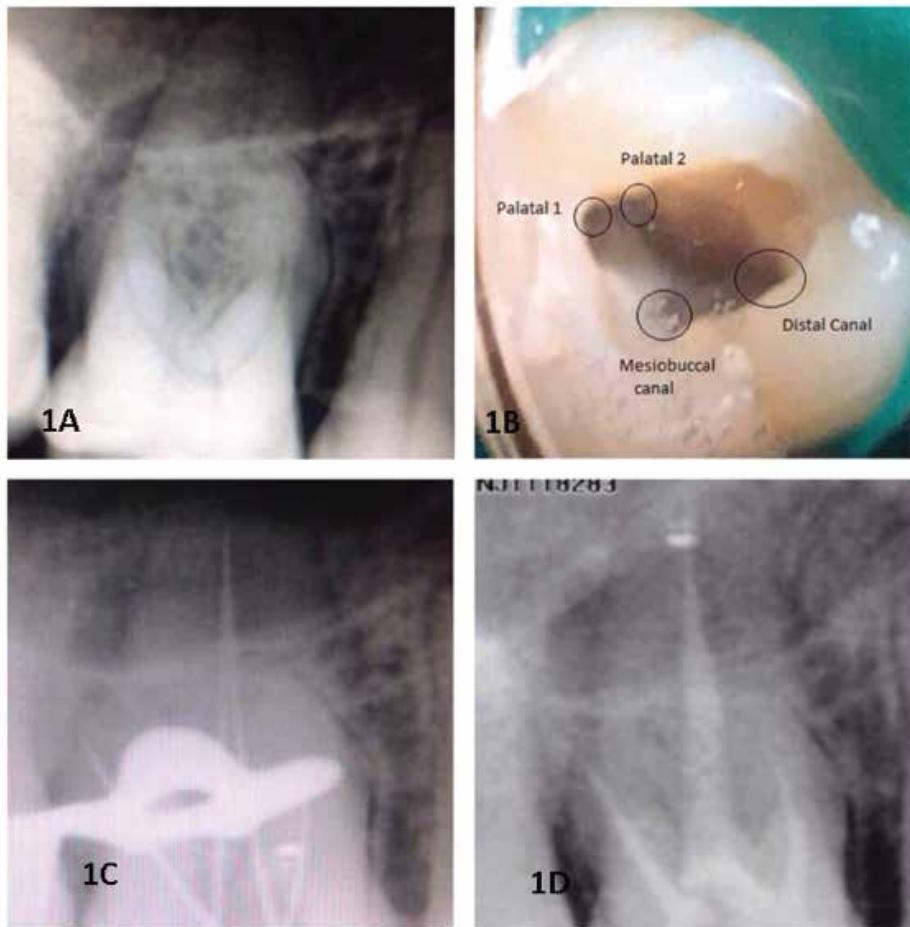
Preoperative radiograph, Figure 1B: Access cavity preparation and canal negotiation, Figure 1C: Working length determination, Figure 1D: Radiograph showing obturated canals.
